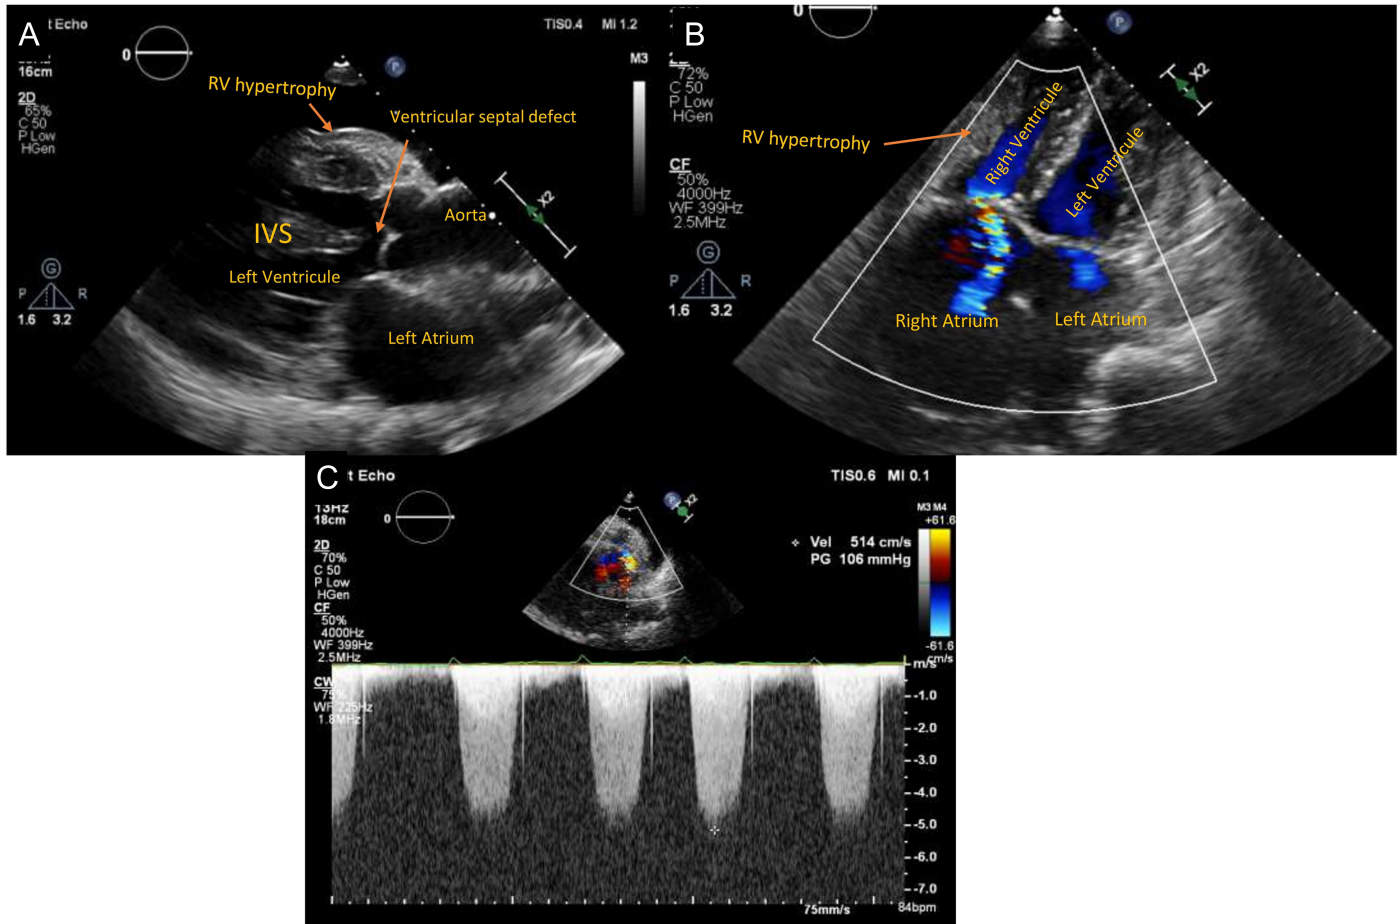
Transthoracic echocardiography indicates a ventricular septal defect, overriding aorta, right ventricular hypertrophy, and biatrial dilatation (A, B). Parasternal short-axis view demonstrates that the pressure gradient across the pulmonic valve reached 106 mmHg (peak) (C). IVS, interventricular septum; RV, right ventricle.
